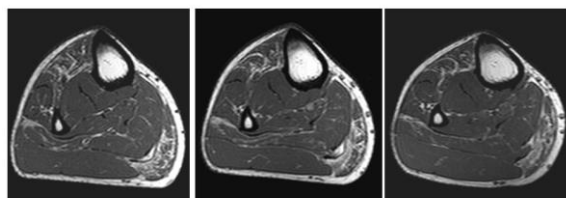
Muscle imaging before and after aerobic training FES. T1-weighted axial images of the right leg: he had increased 6MWT and increased muscle mass at MRI. Patient performing cycling FES
